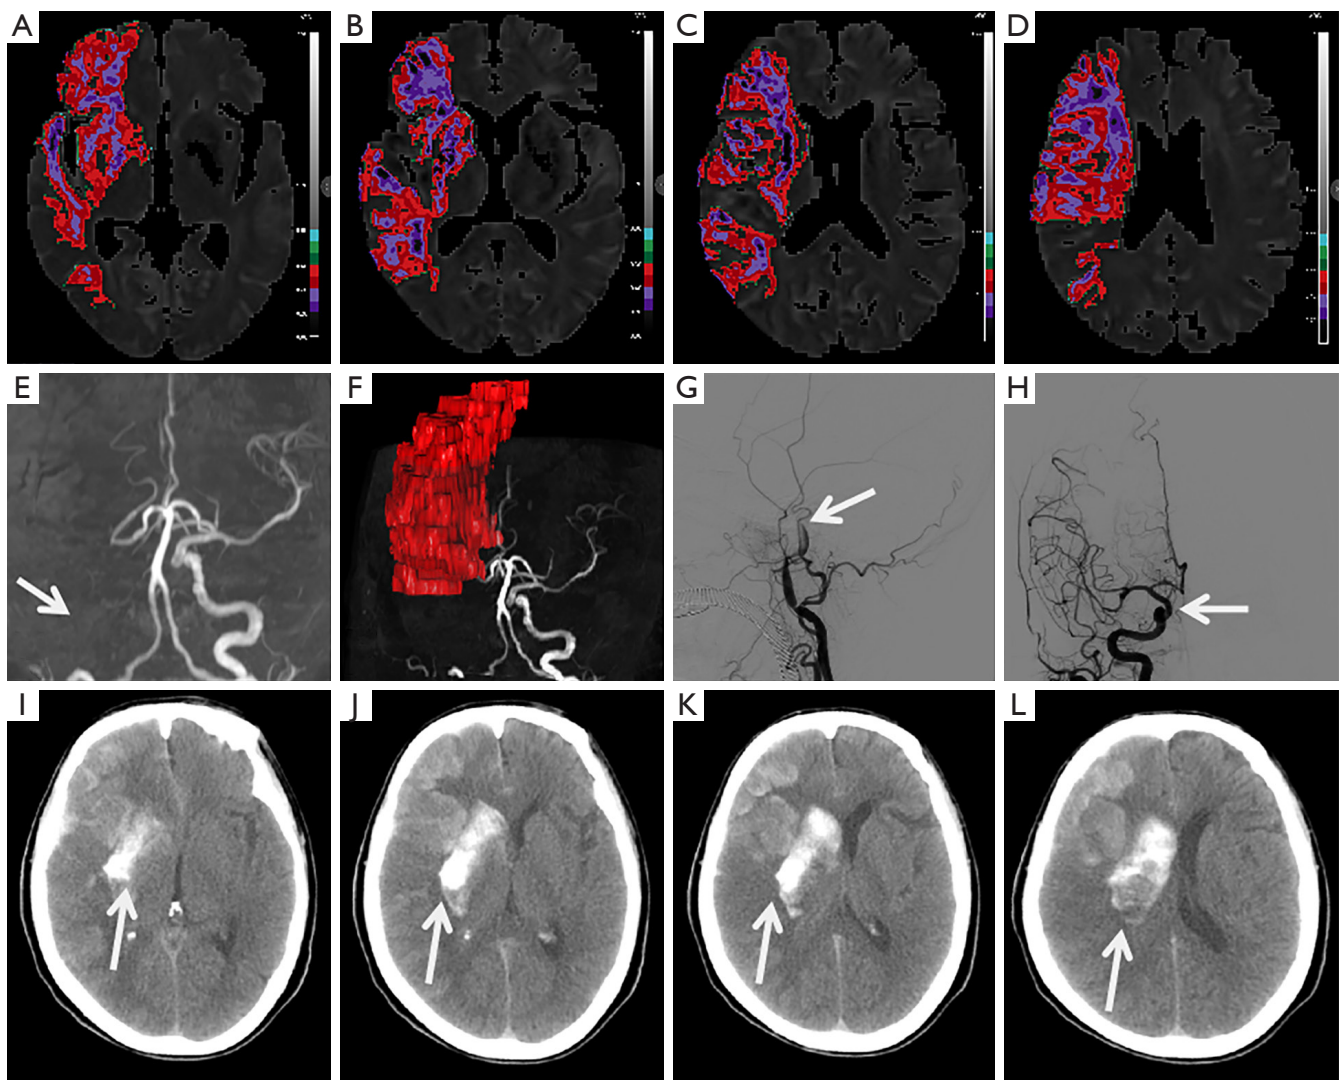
Imaging of a patient with PH2. (A–D) Preoperative ADC map showing the ADC value distribution in the infarct core. The severity of the ischemic area is represented by different colors with related ADC value range (unit: $10^{-3} \text{ mm}^2/\text{s}$): bright red, 0.5–0.6; dark red, 0.4–0.5; light purple, 0.3–0.4; and dark purple, <0.3 . The volume (unit: mL) of the area with $\text{ADC} < 0.4$ is 44.25. (E) MRA image before EVT showing right internal carotid artery (RICA) occlusion (white arrow). (F) Image fusion using MRA and DW images. DSA image before (G) and after (H) EVT showing RICA occlusion (mTICI 0) (G, white arrow) and complete recanalization (mTICI 3) (H, white arrow). (I–L) Follow-up CT shows a patchy and wedge-shaped hyperdense area in the RMCA territory and right ventricle along with a substantial mass effect (white arrows), which indicates PH2. PH, parenchymal hematoma; ADC, apparent diffusion coefficient; MRA, magnetic resonance angiography; EVT, endovascular therapy; DW, diffusion weighted; DSA, digital subtraction angiography; RICA, right internal carotid artery; mTICI, modified Thrombolysis in Cerebral Infarction scale; CT, computed tomography.
